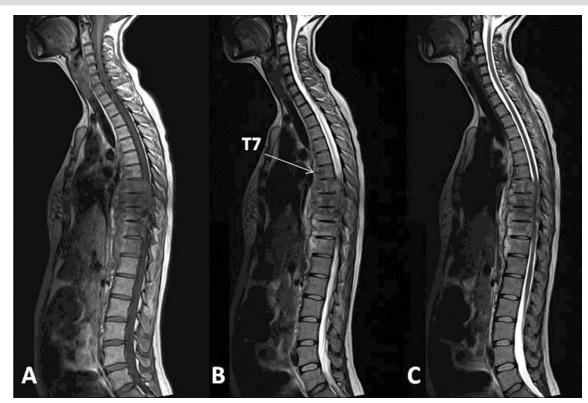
A 30 year old female with atypical spinal tuberculosis. MRI of the thoraco-lumbar spine. A- Sagittal T1 weighted image. B, C- Sagittal T2 weighted images, showing contiguous vertebral body involvement from T7 to T12 level with preserved intervertebral discs associated with prevertebral lobulated lesion and spinal cord compression due to epidural extension of the lesion. Technique: 3Tesla MR scanner, sagittal T1- TSE sequence (TE 9.3, TR 600), sagittal T2- TSE sequence (TE 104, TR 4000).
